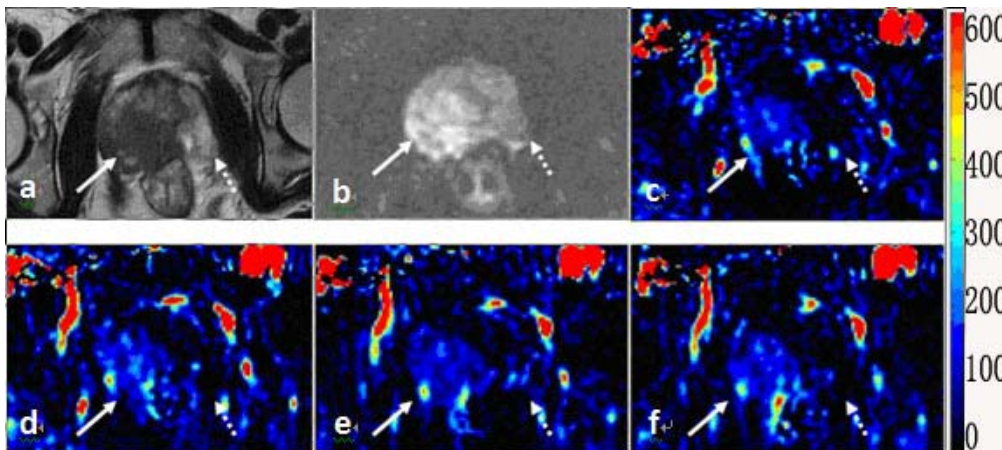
(a-b) A 77-year-old man with biopsy proven cancer at right peripheral zone. The cancer showed low signal in T2 and high signal in DWI; (c-f) The corresponding BF mappings with different TI.
